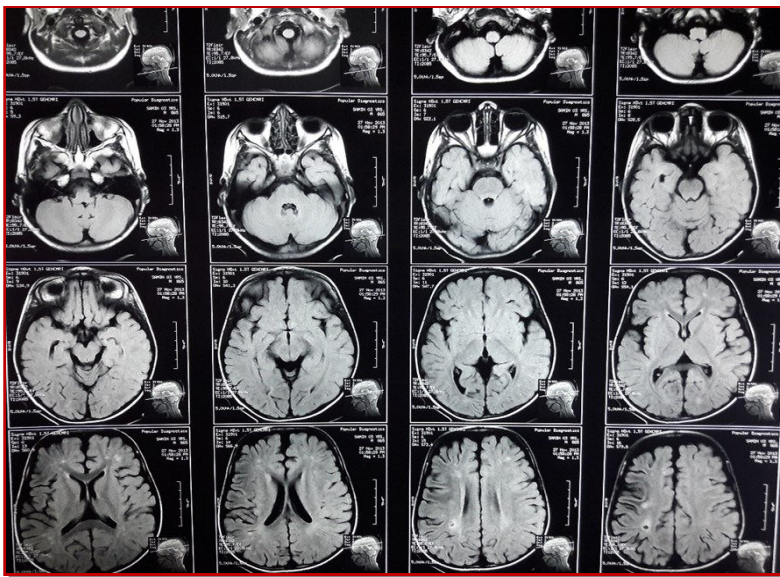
Computed tomography of the brain showed bilateral intraventricular hemorrhage with old infarct with development of arterial confluent in right white matter and atrophy of the brain
